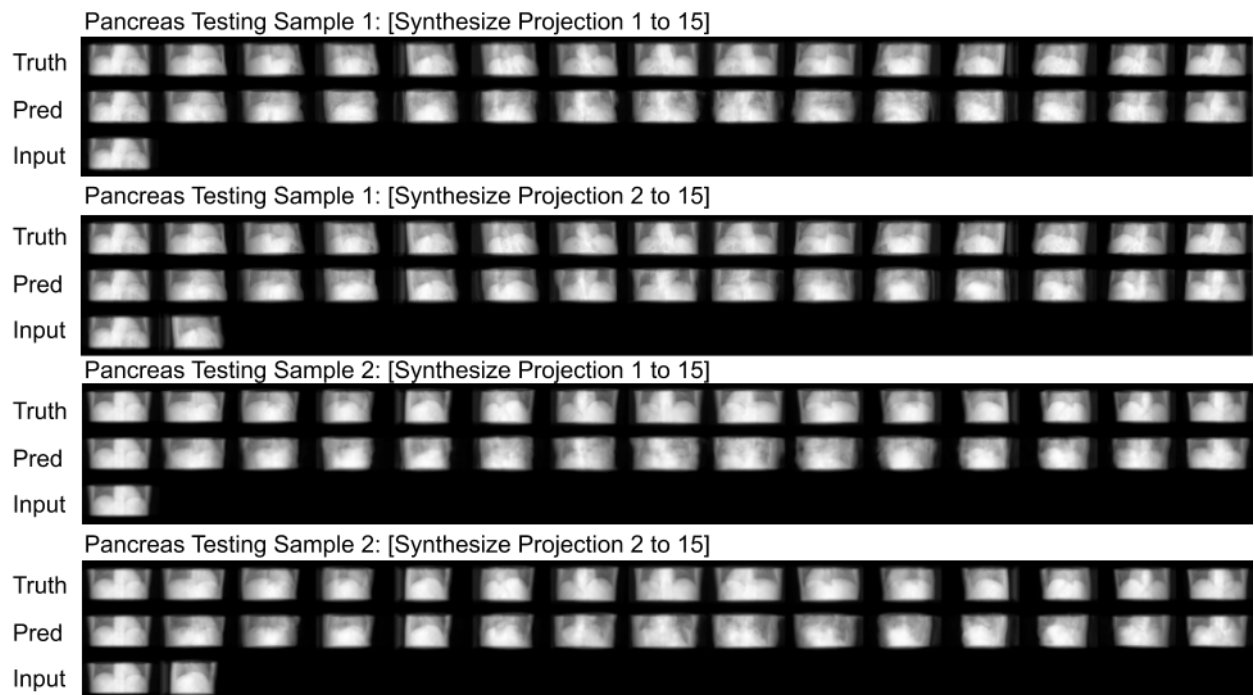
X-ray image generation results of two pancreas testing samples. Ground-truth and predicted novel-view X-ray images from 15 view angles when 1 or 2 projections are inputted.
